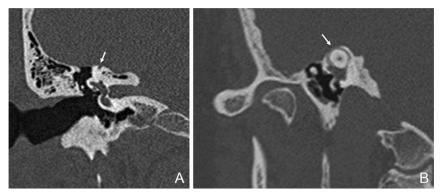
High-resolution temporal bone CT scan showing an SSCD (arrow) on the coronal plane (A) and sagittal oblique (B).
